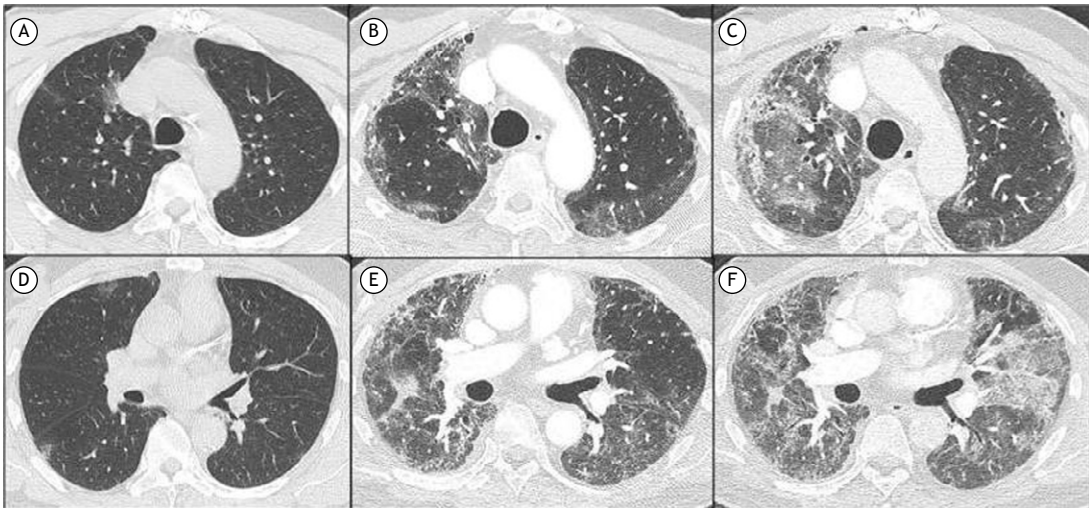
Chest CT scans demonstrating mild ground-glass opacities (GGO) and otherwise preserved lung parenchyma a few days after symptom onset (A and D); persistent peripheral GGO in the upper lobes and GGO, reticulation, and traction bronchiectasis in the lower lobes two months after symptom onset (B and E); new GGO and consolidations superimposed to the previous pattern on readmission (C and F).
